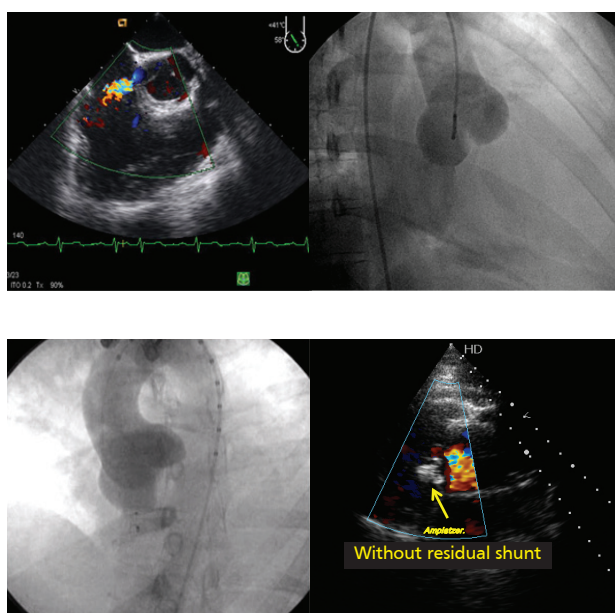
Aorto-right atrial fistula. A. Left: Transesophageal echocardiography at the aortic level showing leak from the aorta to the right atrium. Right: Angiographic image showing aneurysmal dilation of the sinus of Valsalva and right atrial filling through the fistula. B. Left: Deployed Amplatzer® device with absence of contrast passage into the right atrium. Right: Transesophageal echocardiogram showing the position of the Amplatzer® device (arrow) and the absence of residual shunt.
